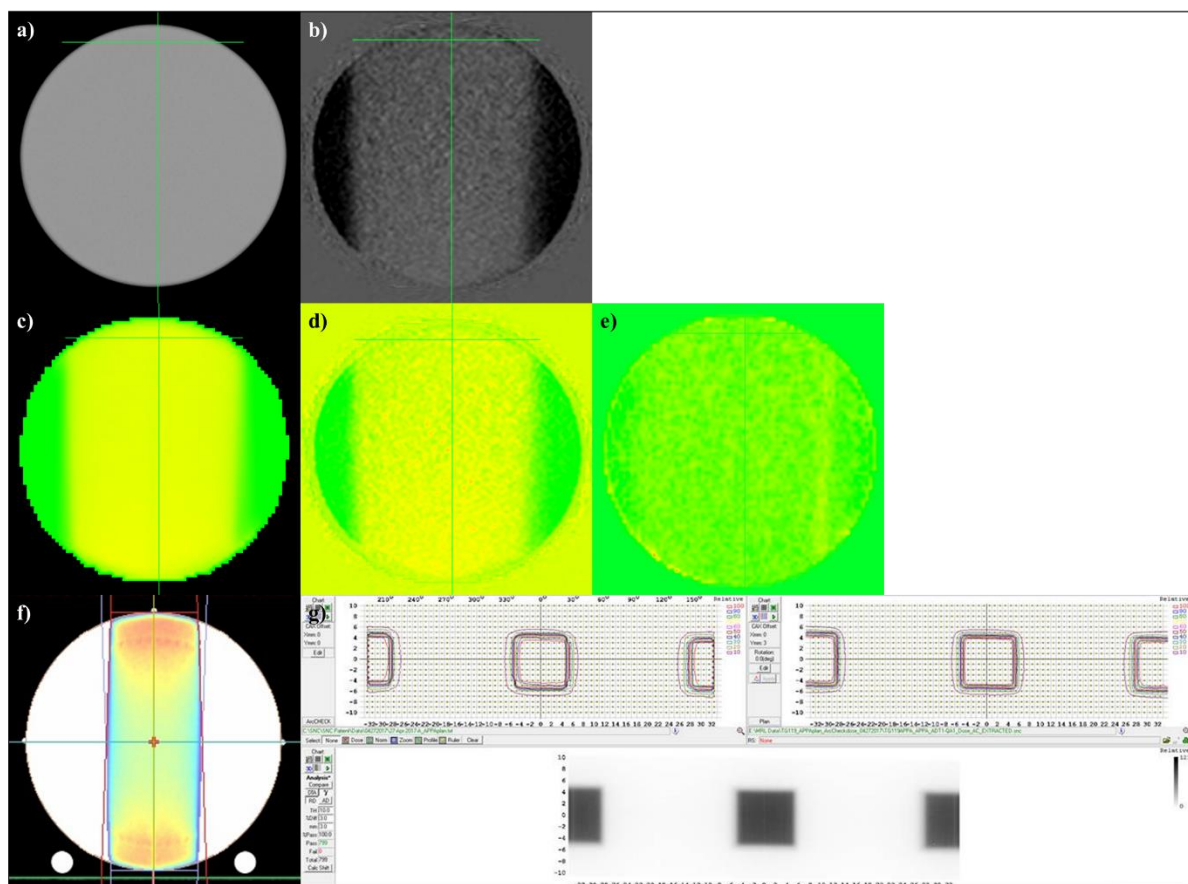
a) CT of large uniform FXG, b) T1-weighted T1 CE image, c) Monaco TPS dose overlaid on CT, d) T1 CE relative dose, e) gamma map of T1 CE dose, f) Monaco TPS dose on CT of ArcCHECK-MR, and g) delivered and planned relative dose comparisons for AP PA TG-119 plan.
